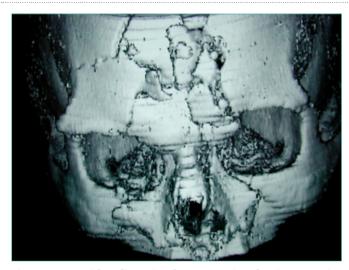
CT scan with 3-dimensional reconstruction showing extensive facial trauma.
